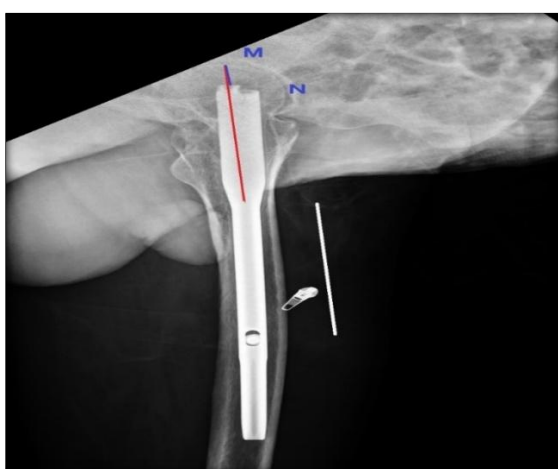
Postoperative X-ray at 3 months: Tip Apex distance (MN) calculated from both AP and Lateral plains-23 mm
